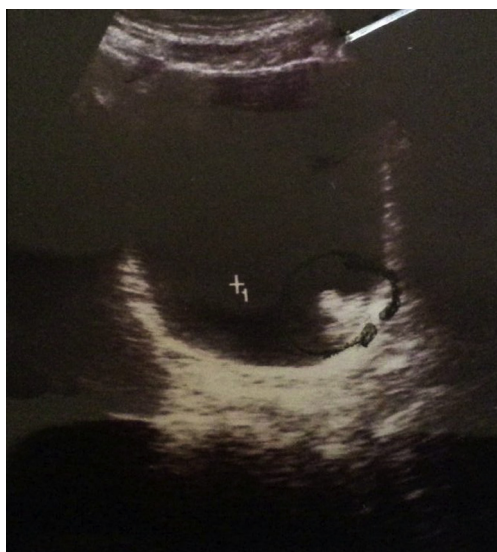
An ultrasonogram showing the soft-tissue lesion in the left bladder wall.
